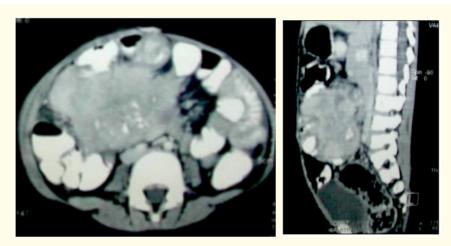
CT scans of the abdomen showing a mass encasing the small bowel with calcification.
